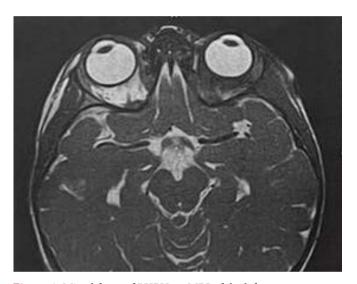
Mixed form of PHPV on MRI of the left eye.
